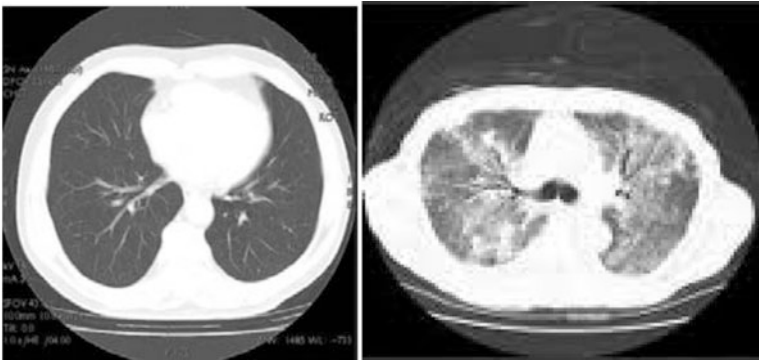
Left:* CT scan of lung with normal parenchyma. *Right:* CT scan of lung with fluid filled alveoli due to ARDS
